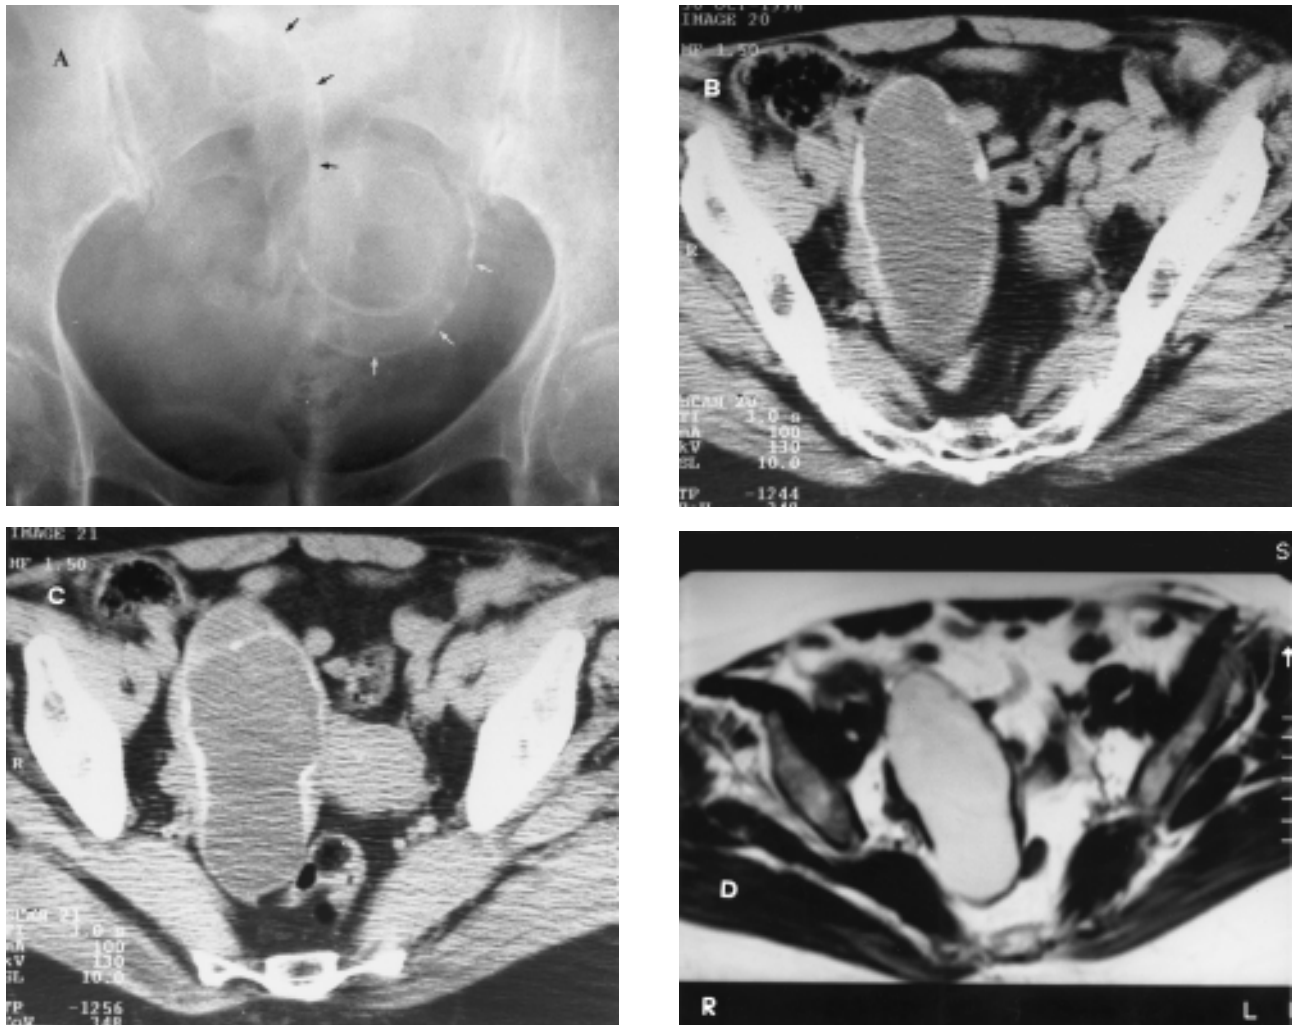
A. Plain x - ray of the lower abdomen shows two calcified lesions; a leiomyoma on the left (white arrows) and an ovoid linear calcification on the right (black arrows). B, C. Axial CT scans revealed the cystic lesion with rim calcification and its relationship with the cecum. D. Axial MR T2-weighted image shows the mucocele with high signal intensity and the rim calcification with low signal intensity.
